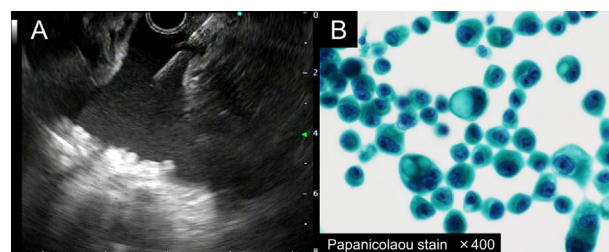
A. Transrectal endoscopic ultrasound-guided paracentesis was performed using a 22-gauge needle for ascites in the pelvis. B. Cytopathologic testing of the aspirated fluid showing malignant cells characteristic of a poorly differentiated adenocarcinoma.
